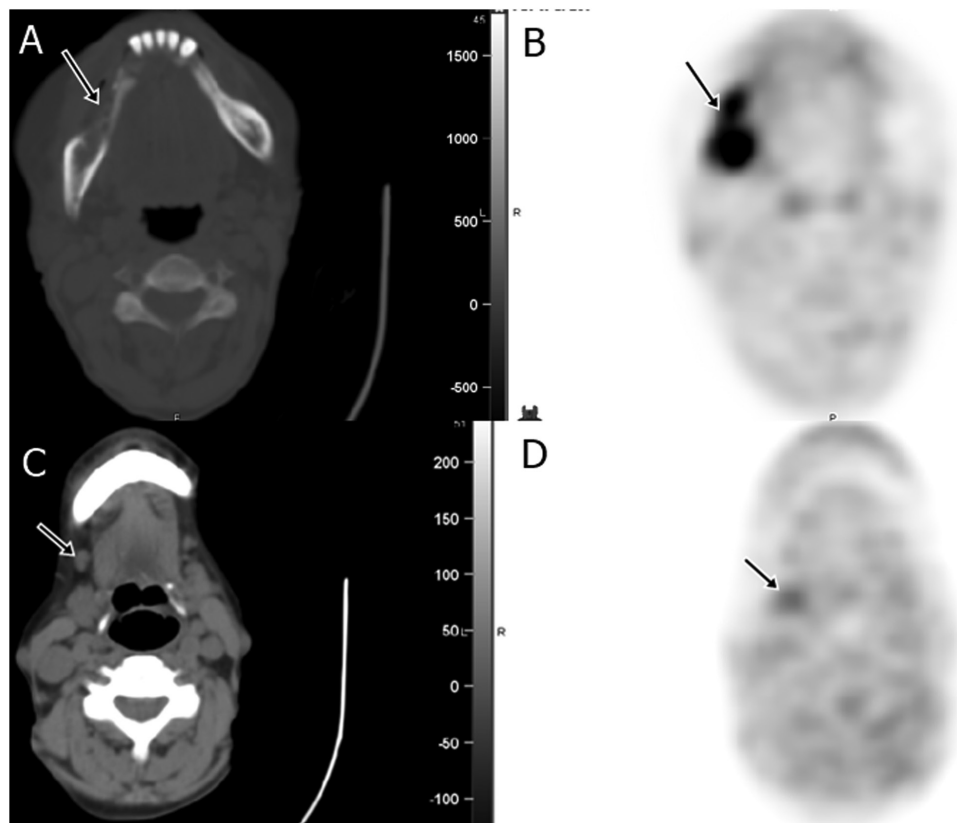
A 68-year-old woman with right mandibular squamous cell carcinoma (patient 4). Staging PET/CT showed (A) bone destruction and the premandibular soft tissue involvement and (B) intense FDG uptake. There was a 1.3 cm right level IB node considered as metastasis on the diagnostic CT report. (C and D) However, there was only minimal uptake of the lymph node on PET (arrows). Surgical pathology of this lymph node was negative for tumor. FDG, fluorodeoxyglucose; PET, positron emission tomography.
